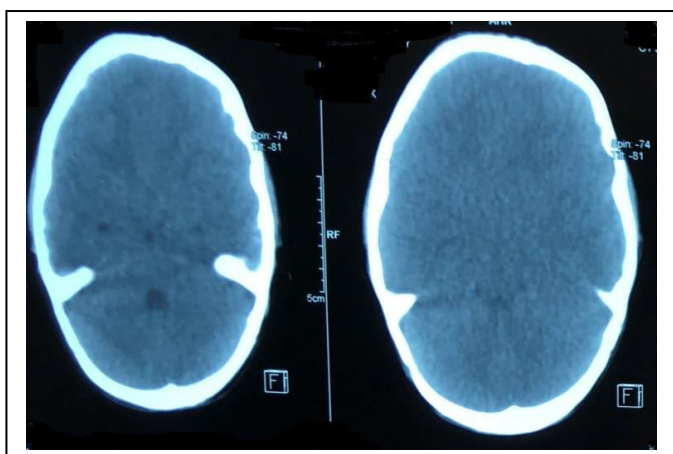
Brain CT scan of patient one shows thick skull with sulcal effacement (A) and closure of all sutures except for lambdoid that found obvious diastasis (B).
